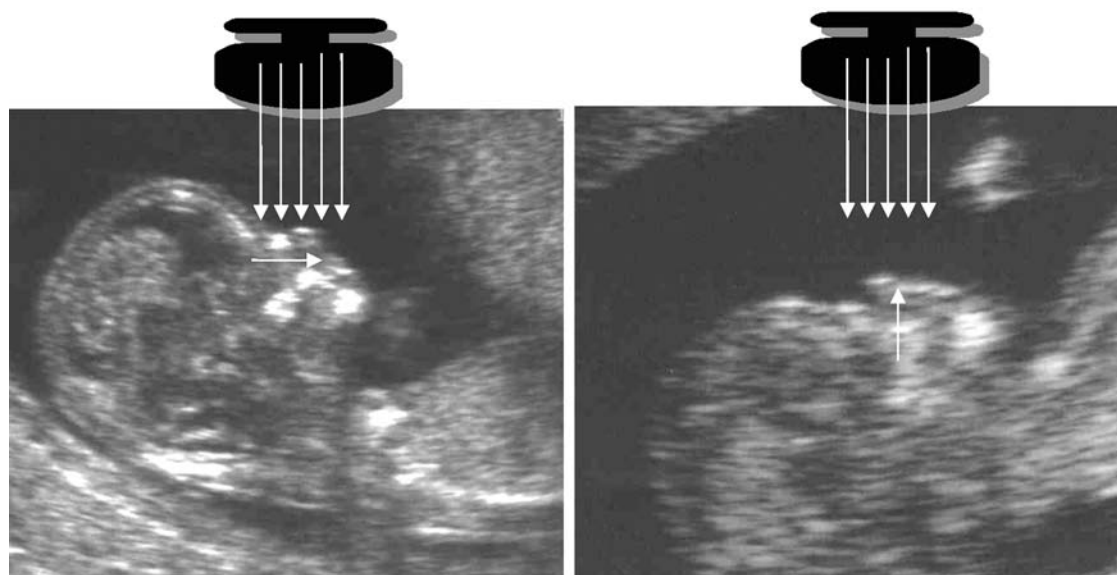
The best angle of insonation to assess the nasal bone in the first trimester is 90° to the longitudinal axis of the nasal bone (i.e., the beam of the ultrasound perpendicular to the longitudinal axis of the nasal bone) (left). Evaluation of the nasal bone should not be attempted with either a 0° or 180° angle of insonation (i.e., with the ultrasound beam parallel to the longitudinal axis of the nasal bone) (right).
